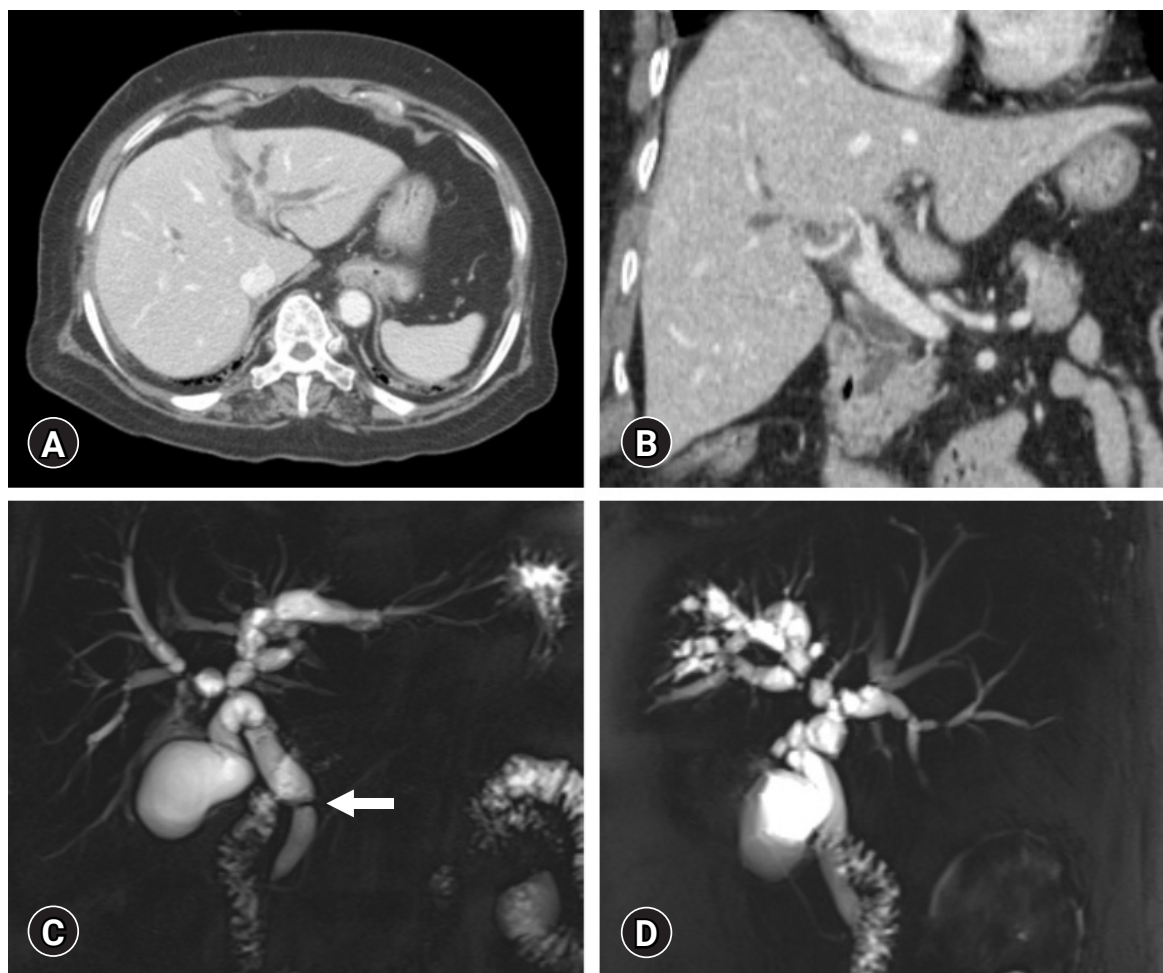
Initial imaging studies. (A, B) Abdominal computed tomography shows diffuse dilatation of the intra- and extrahepatic bile ducts. (C, D) Magnetic resonance cholangiopancreatography shows multifocal biliary webs without anomalous pancreaticobiliary junction. Arrow indicates the location of a common bile duct web.
